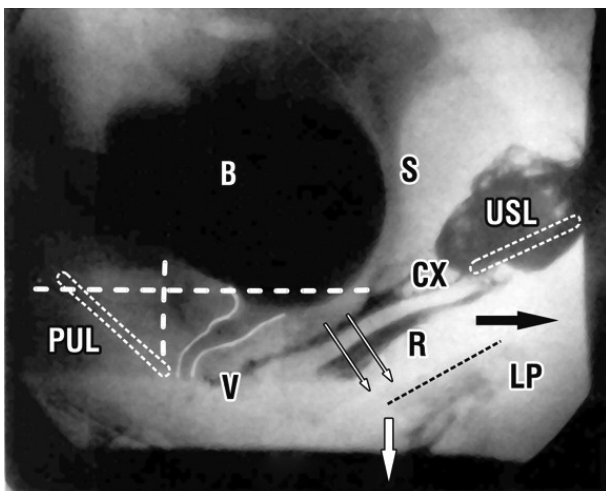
Micturition X-ray. Levator plate (LP) vector pulls the bladder base and urethra backwards; the downward vector (white arrow) pulls downward on the posterior wall of the urethra opening it out “funneling”. This action effectively shortens the urethra. This action also relies on LP being tensioned from pubic symphysis to sacrum. If the right side of LP is ruptured, only the left side can be tensioned, so only the left side is shortened. This scenario explains urinary stream divergence to the left and “spraying”, as there will be a smoother flow of urine on the left side and much more turbulent flow on the right side. The important factor here is that the frictional resistance between the urine flow and the urethral wall is exponential, inversely to the 5th power of the radius.
